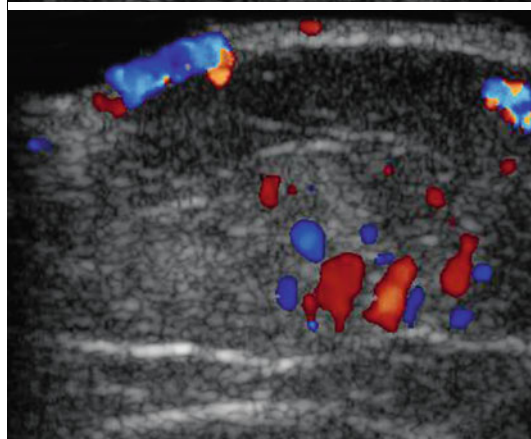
Color Doppler sonographic grading of vascularity during the different phases of hemangiomas
